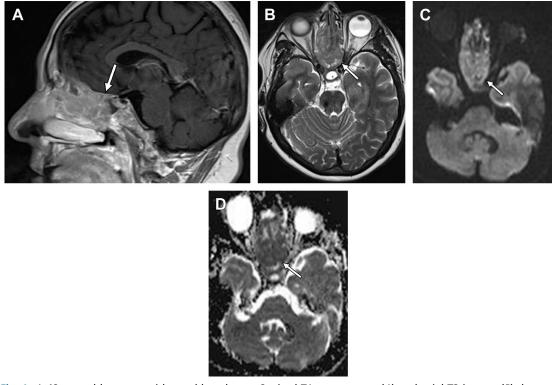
A 48-year-old woman with nasal lymphoma. Sagittal T1 postcontrast (*A*) and axial T2 images (*B*) demonstrate an avidly enhancing, T2 hypointense mass (*arrows*) filling the ethmoid sinuses with destruction of the osseous walls of the ethmoid sinuses. Note the hyperintensity of this mass relative to the brain on a diffusion-weighted (high b value, B-900) image (*arrow*) (*C*) and hypointensity on the ADC map (*D*). The brain serves as a useful internal control in DWI; the brain generally restricts diffusion to a greater extent than most physiologic tissues in the head and neck. This patient's densely cellular tumor (nasal lymphoma) restricted water diffusion to a greater extent than the brain and well above other skull base and neck soft tissues at this level.
